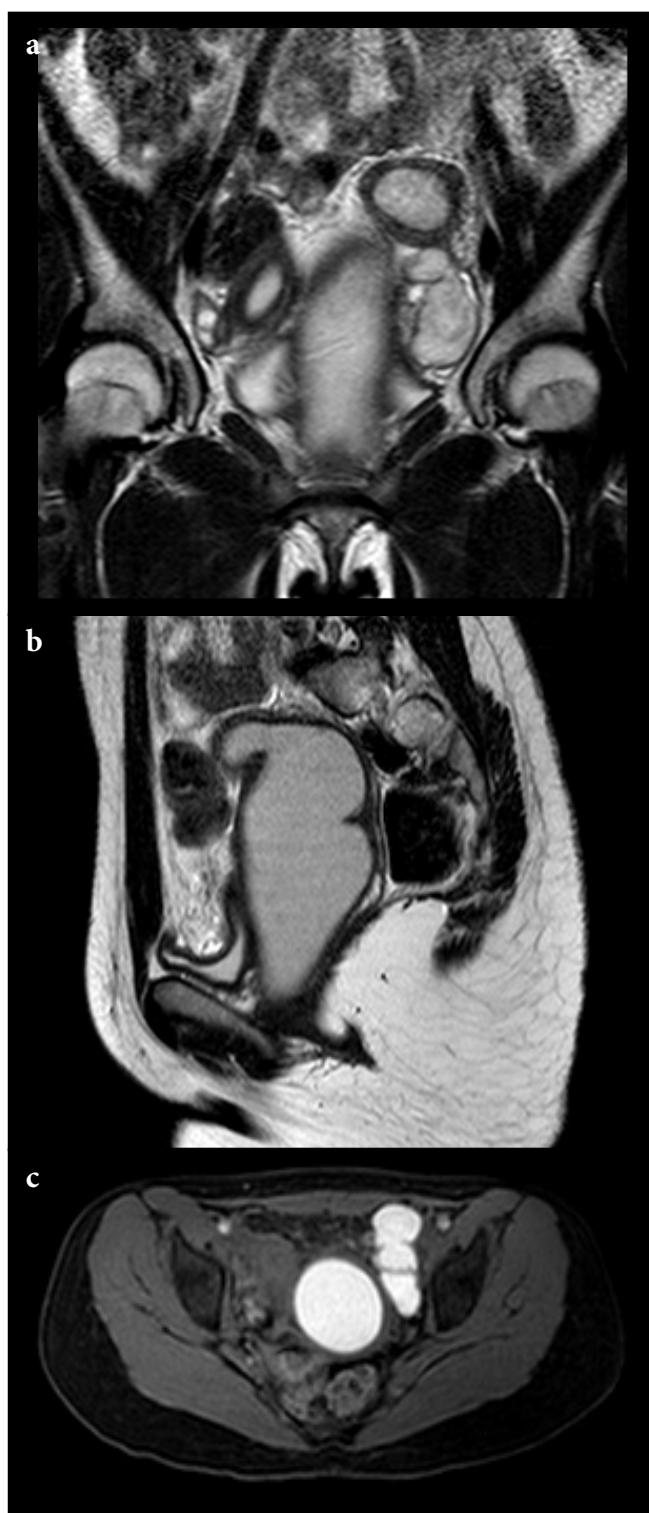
In T2-weighted coronal MRI; Two separate endometrial cavities (a), enlargement of the cervical canal (arrow) with sudden termination of the vaginal fornix in the sagittal image (arrow), hemorrhagic collection in the endometrial cavity with obstructed hemivagina (b). In the axial fat-sat image; hematosalpinx image is observed in the left tuba (long arrow) (c).
